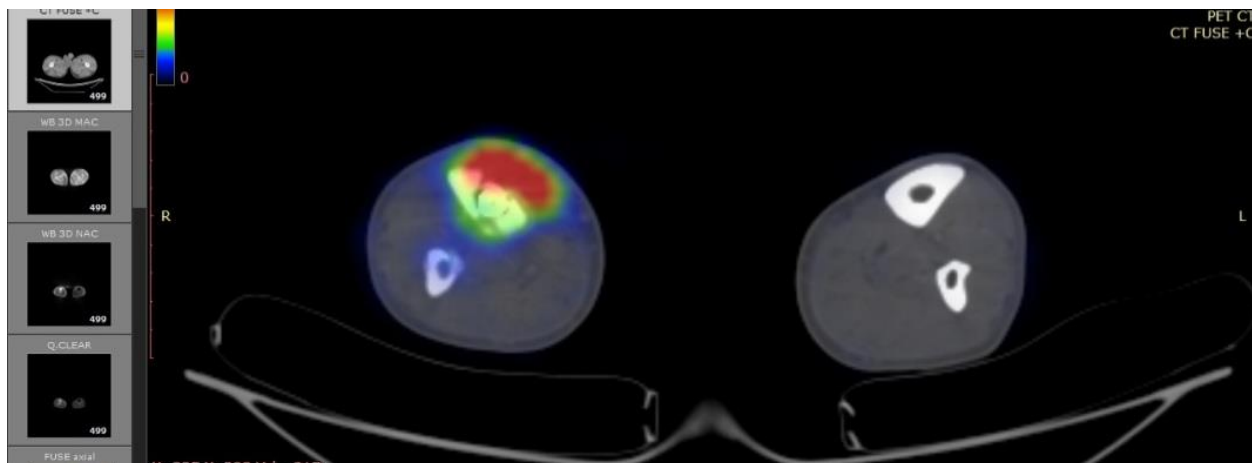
PET CT scan was done for diagnosis of osteomyelitis and assessment the extent of the disease.
